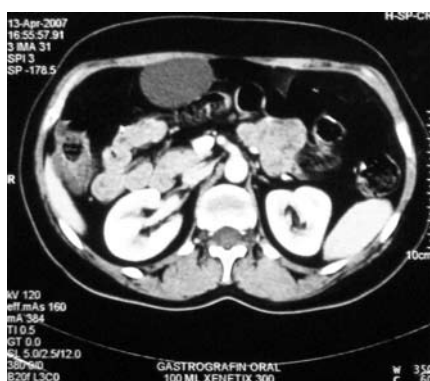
Abdominal CT scan with intravenous contrast media used showing a water-density mass attached to the anterior abdominal wall. A well circumscribed area of low attenuation in contact with the abdominal wall is identified.
